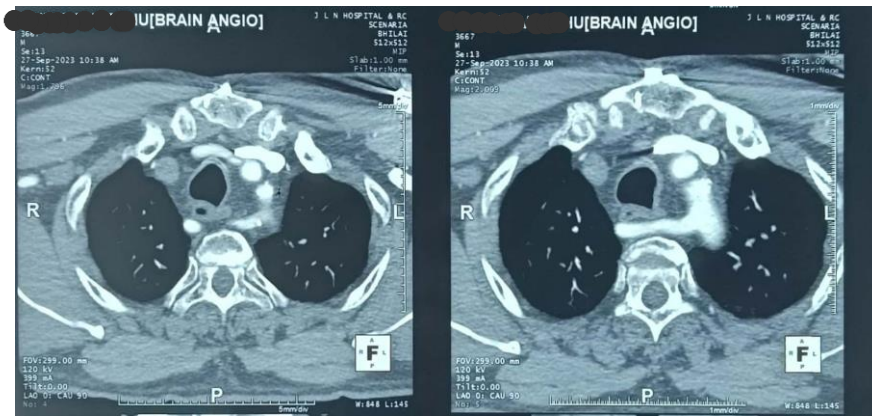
Axial cut CT Angiography showing aberrant vessel arising from distal arch of aorta as a separate branch and courses between the dorsal vertebra and the oesophagus
